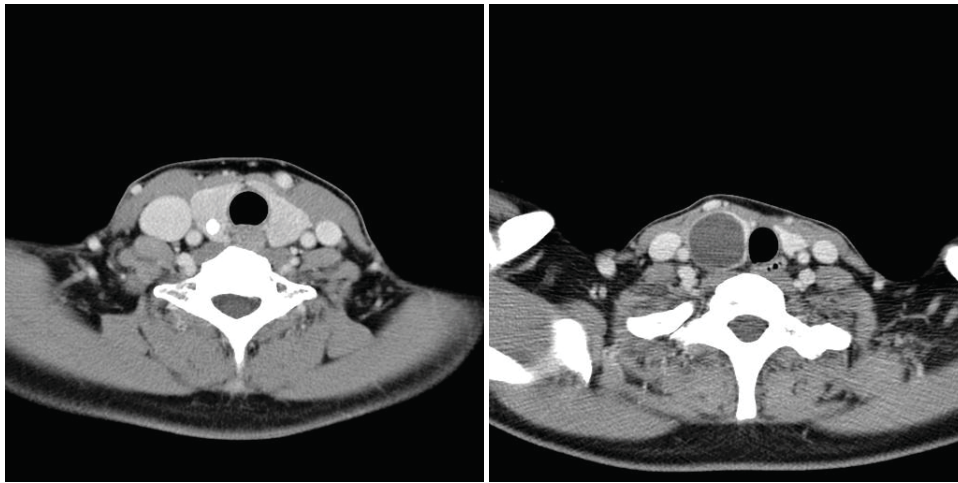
A) Computed tomographic image shows a 0.7 cm sized calcified nodule with no extrathyroidal extension and no lymph node metastasis in patient 1. B) In patient 2, the computed tomographic image shows a 3 × 3 cm-sized homogenous cystic nodule in the right thyroid gland.
